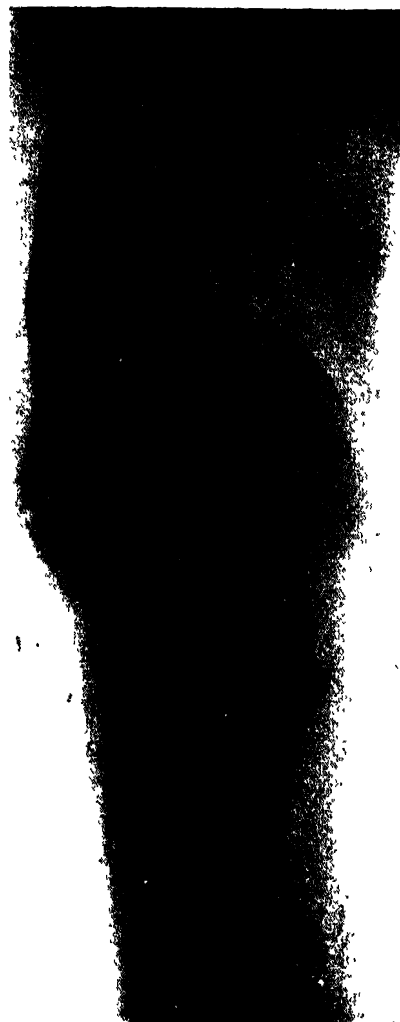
Rickets affecting knee region. Radiograph showing broadening and irregularity of metaphyseal regions and secondary bowing of femur.
